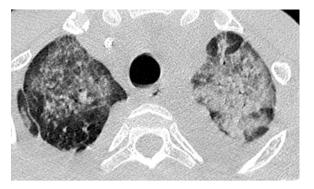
HRCT shows diffuse ground glass opacities.
